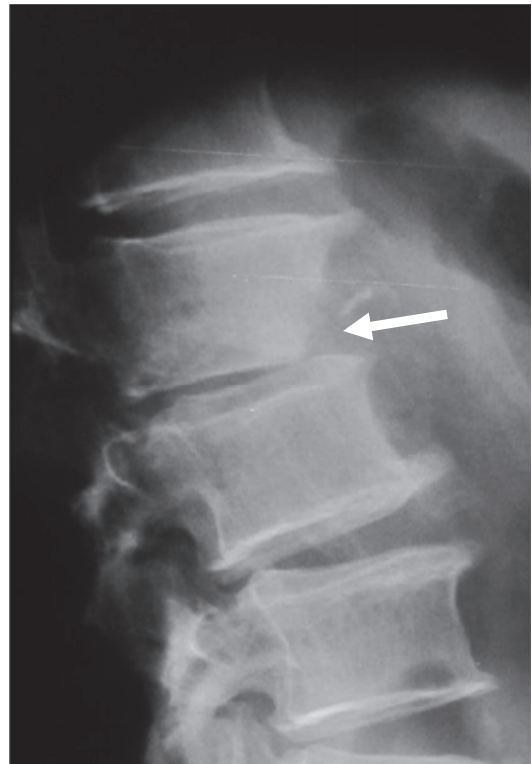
Tuberculous spondylodiscitis of the lumbar spine. Lateral radiograph shows narrowing of the intervertebral disc space with subchondral bone resorption and osteolysis of the adjacent anterior-inferior vertebral body (arrow)
